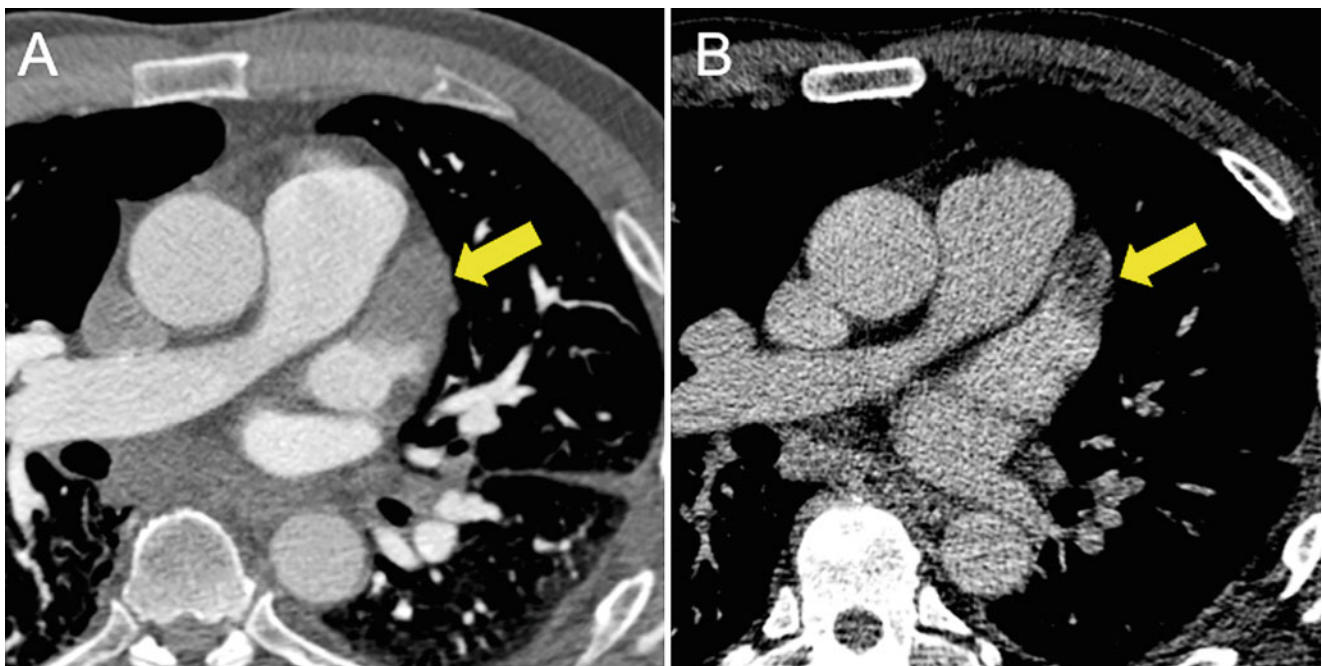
(a) Trans-axial CT image of a patient undergoing a pulmonary vein study during arterial phase shows a filling defect within the left atrial appendage. (b) A non-contrast delayed scan performed within
